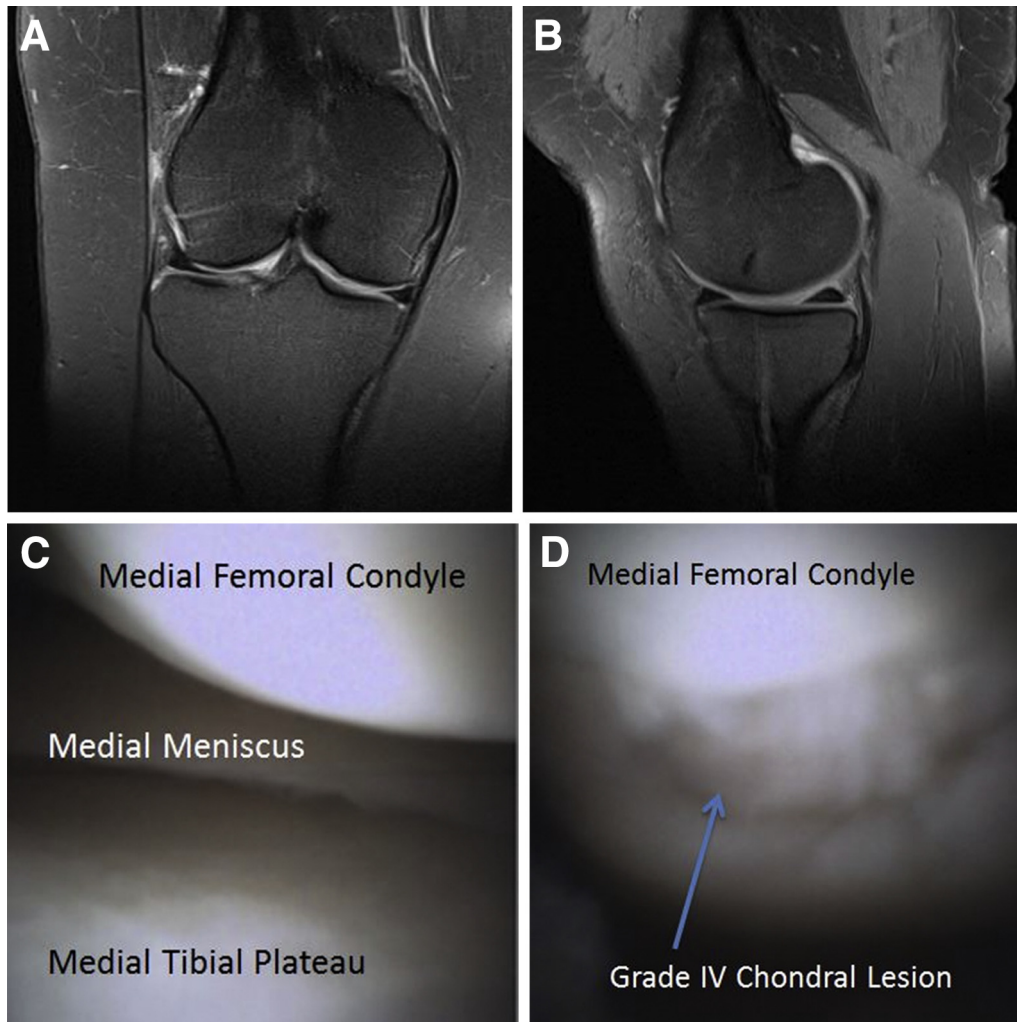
Three-tesla T2-weighted coronal (A) and sagittal (B) magnetic resonance image of a patient with chronic medial-sided right knee pain with minimal chondral damage on advanced imaging. In-office arthroscopy of the medial compartment (C) showed a grade IV chondral lesion on the medial femoral condyle after flexion of the knee to approximately 45° (D) viewed from the anterolateral portal.
